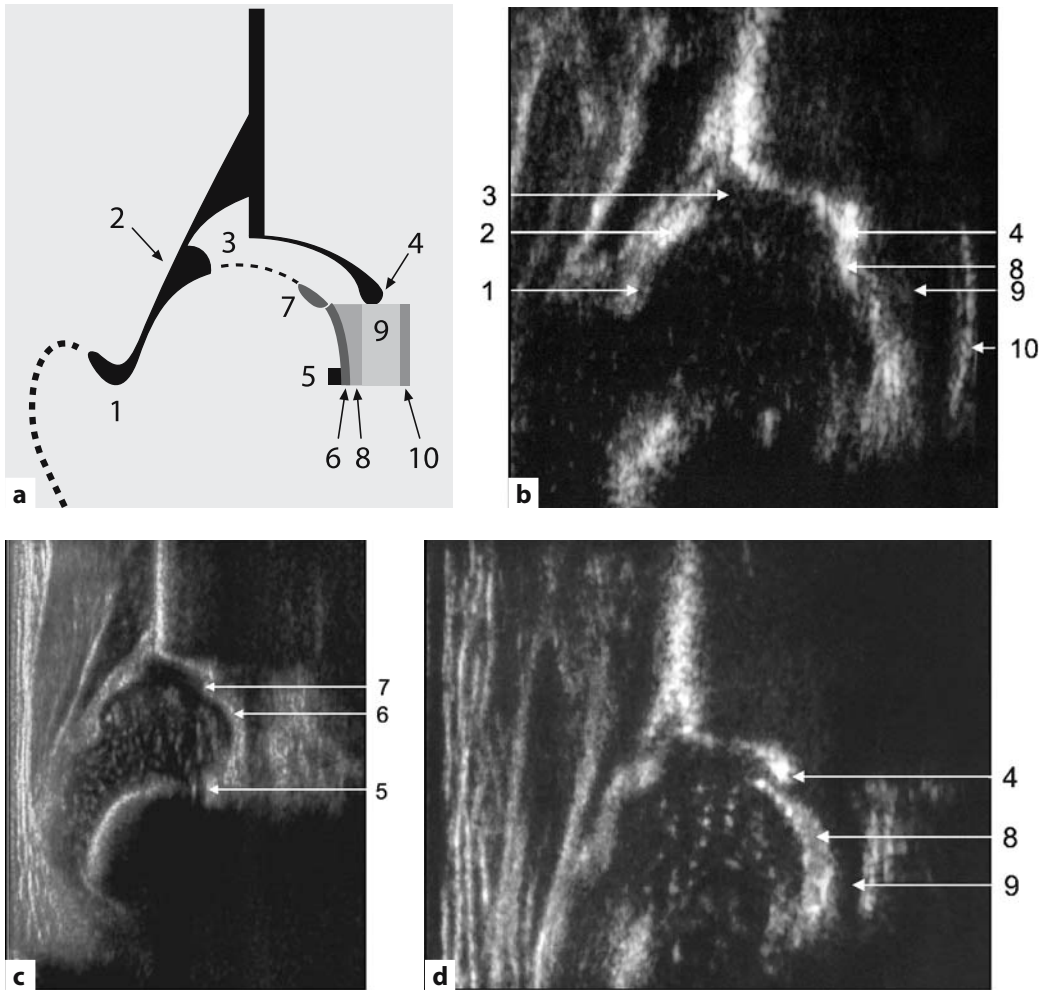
Identifying anatomical structures of the infant acetabulum (as seen on ultrasonography). 1, Synovial fold; 2, labrum; 3, cartilaginous acetabular roof, formed from hyaline cartilage; 4, lower limb of the os
